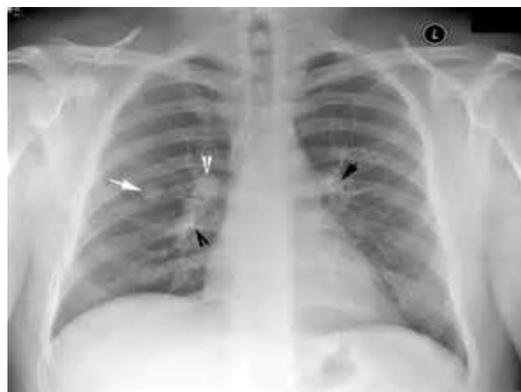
Chest x-ray showing discrete round nodule(s) with round edges without calcification.
